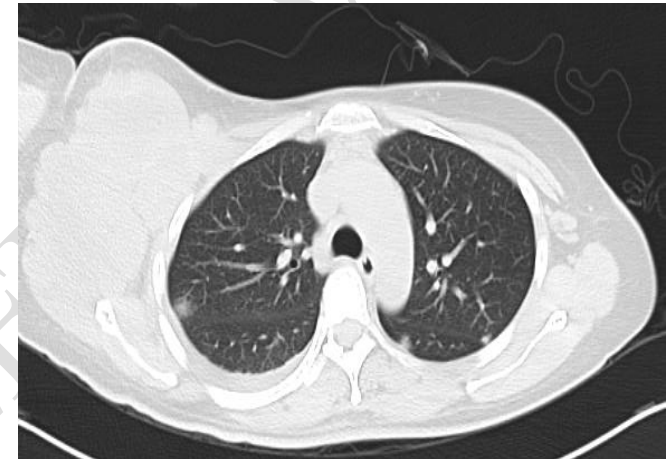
CT Scan showed (4a) axial view and (4b) coronal view of Right lobulated matted mass over axillary and right lateral chest wall suggestive of lymph nodes metastasis. 4(c) Right Anterior mediastinal mass suggestive of lymph nodes metastasis 4(d) Bilateral lung nodules suggestive of metastasis
